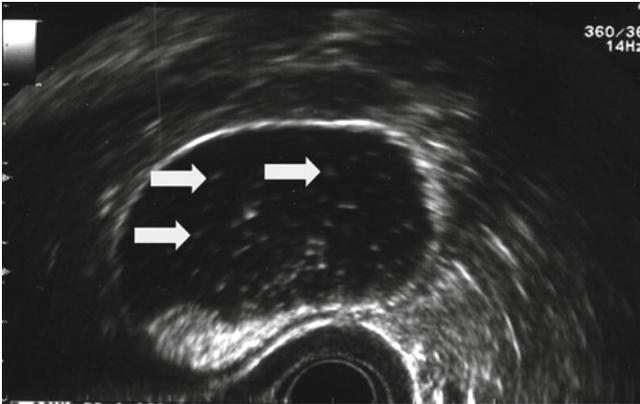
Linear EUS image (7.5 MHz) showing a microlithiasis of the gallbladder (hyperechoic spots without postacoustic shadow, arrows). Note that hyperechoic spots accumulate in the lower part of the gallbladder and form a hyperechoic pseudopolyp (left hand side). Percutaneous ultrasonography had revealed no abnormality in this obese patient after a first attack of acute pancreatitis, and this had been diagnosed as “idiopathic” acute pancreatitis.
